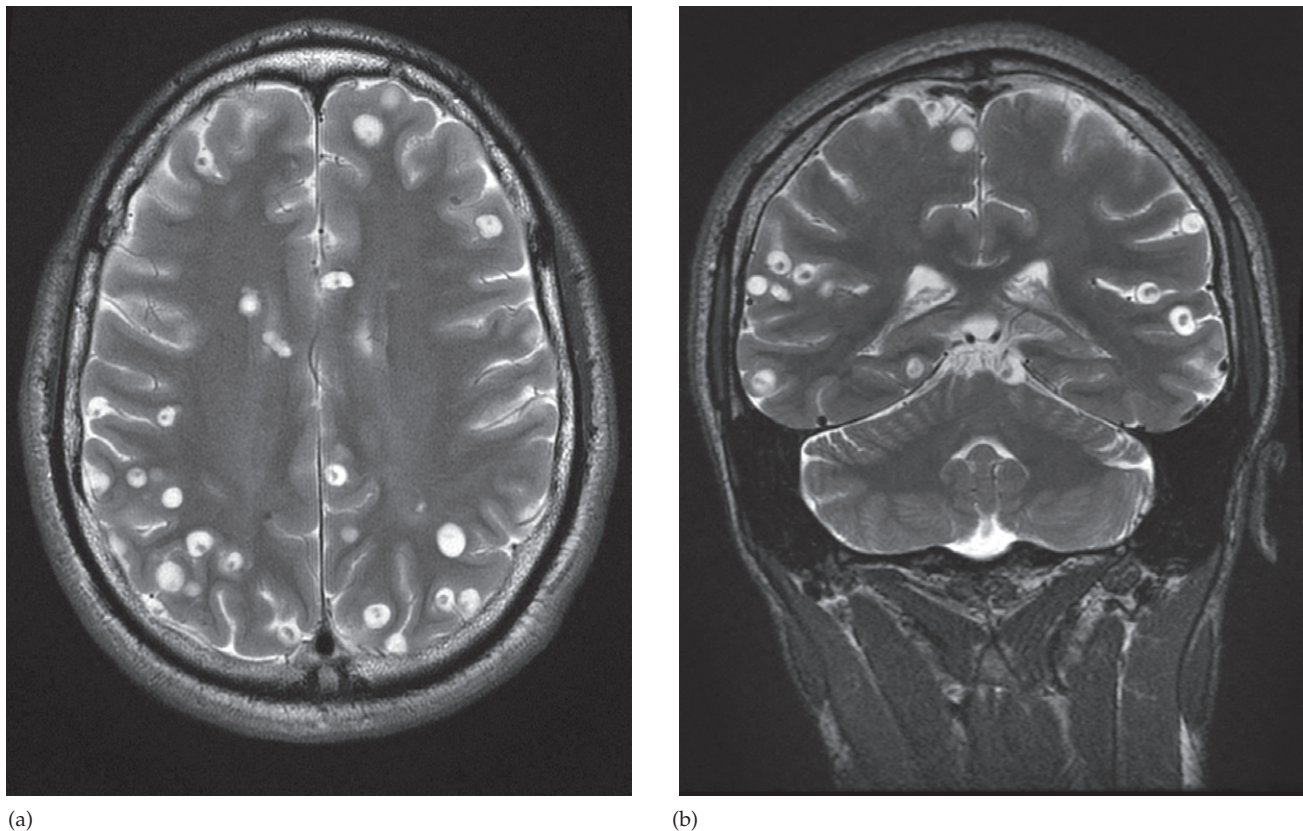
Neurocysticercosis. (a) Axial and (b) coronal T2-weighted MRI showing multiple cysts in the brain and subarachnoid space. Several of the cysts contain a low signal dot which is the headpart (scolex) of the parasite.
